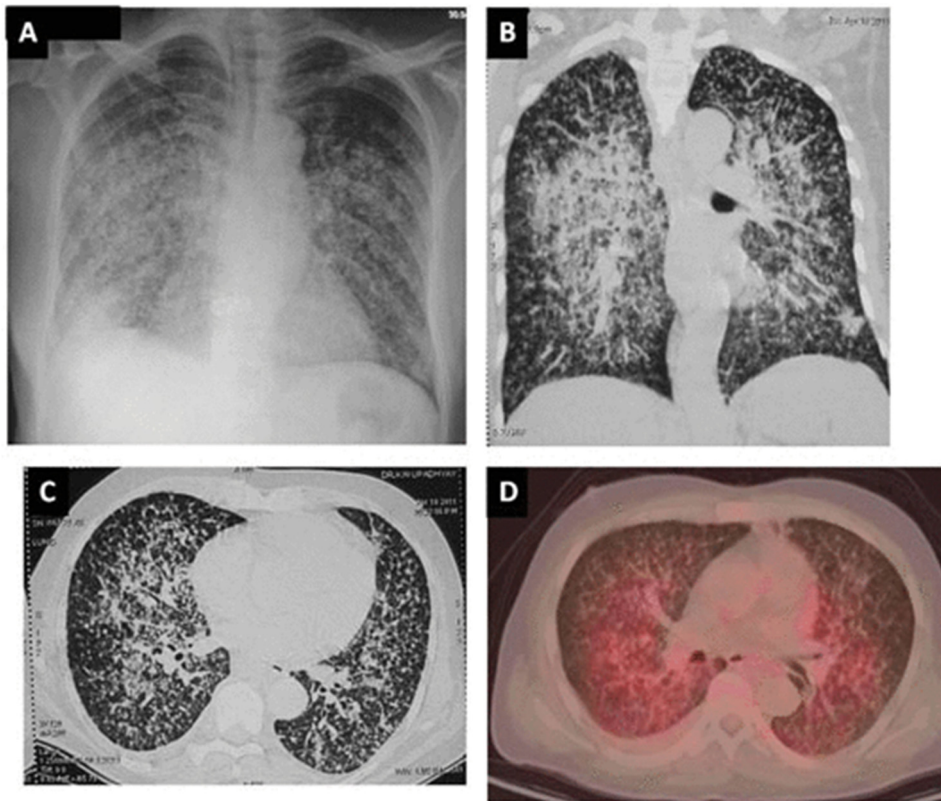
Miliary tuberculosis A) Chest radiograph B) and C) computed tomography D) positron emission tomography-computed tomography from the same patient, all with miliary lesions, predominantly on the right side. Source: Sharma *et al.* 2011 (55)
